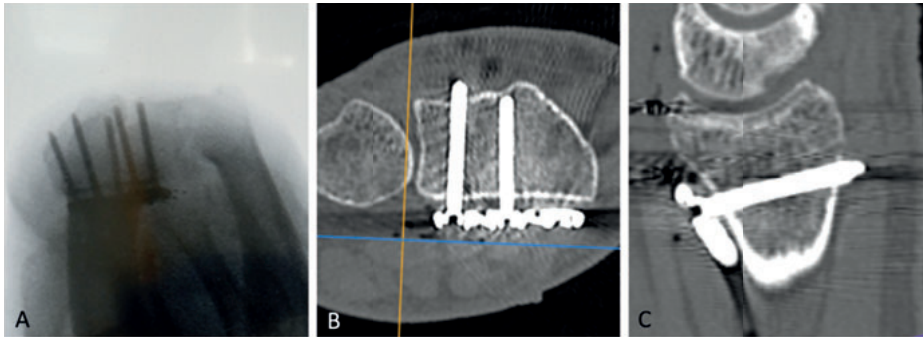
Out of the 16 times the surgeon-observers missed a screw after training, in eight times it concerned the same ulnar screw protruding in the 4th compartment, of which the DTV is depicted in A and, the axial CT-reconstruction in B and the sagittal CT-scan in C: revealing relative proximal plate positioning and therefore the screw protrusion obscured by the dorsal ridge
